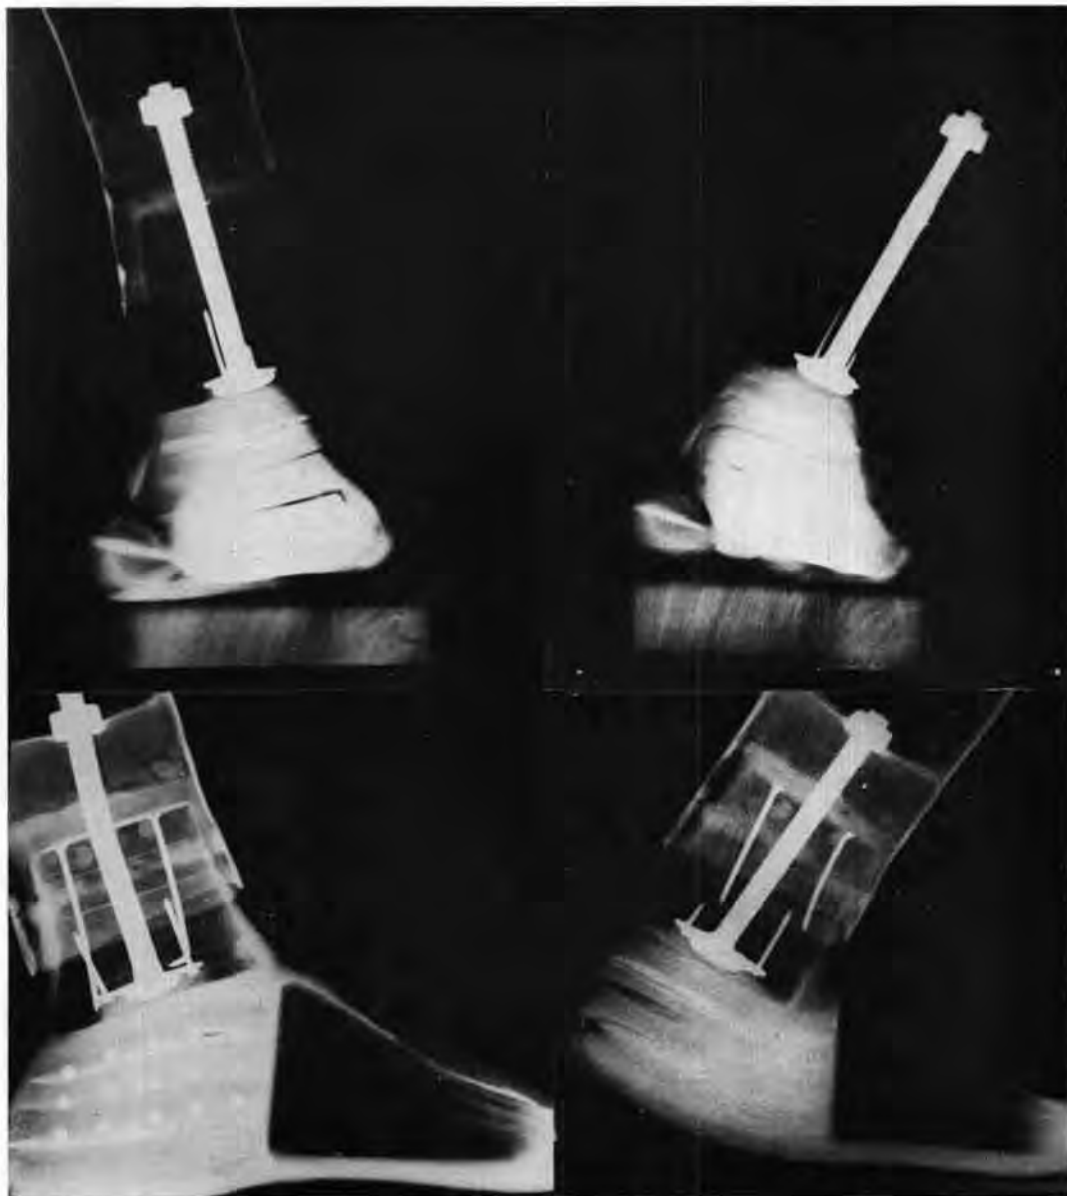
Radiographic demonstration of range of movement. Top left, inversion. Top right, eversion. Bottom left, plantarflexion. Bottom right, dorsiflexion.
